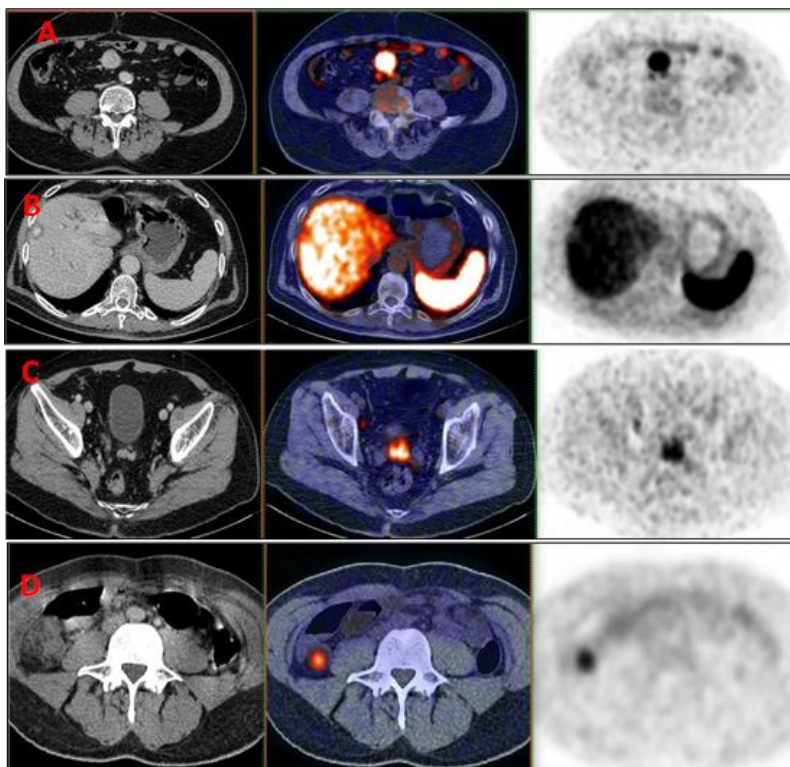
A 47 years old male patient complained of abdominal pain for 4 months duration had imaged-based suspicion of NETs (by abdominal ultrasound and CT). ^{68}Ga DOTATATE PET/CT
